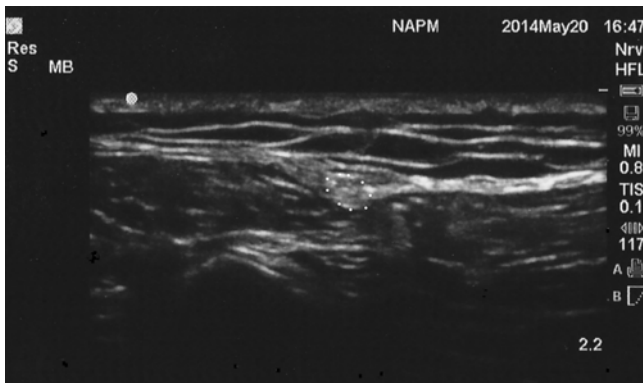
Ultrasound image of the fascial plane containing the lateral sural cutaneous nerve (Image courtesy of Heath McAnally, MD)
